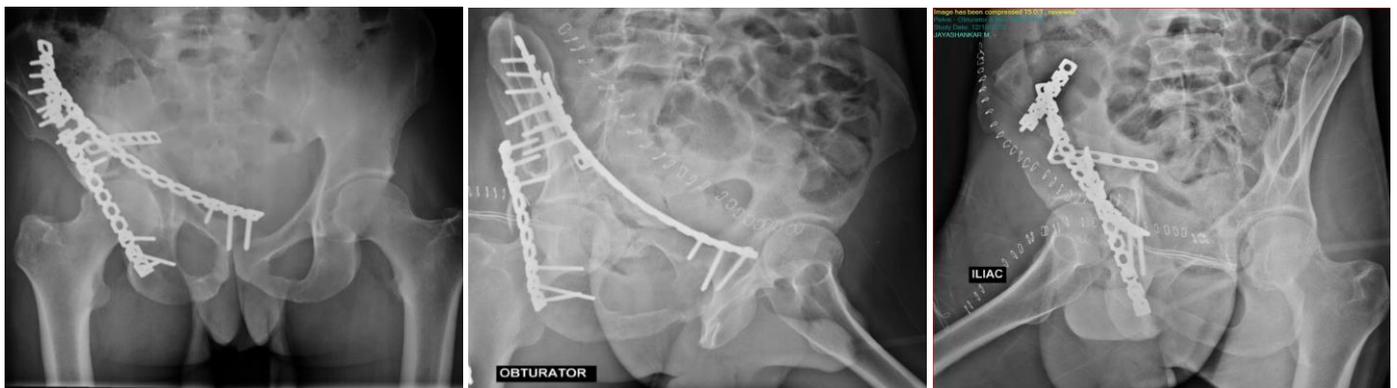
2 years post op xray
